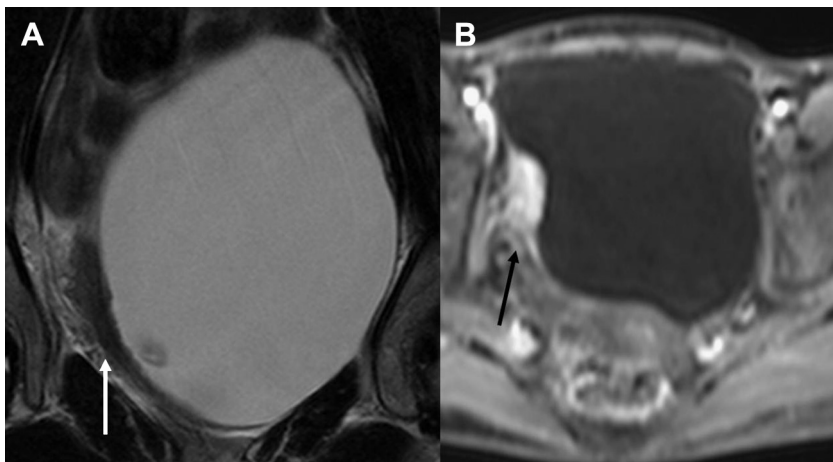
T2-weighted (A) and T1 fat saturated postcontrast (B) axial images. The *arrows* indicate bladder wall invasion and perivesicle extension in keeping with a T3b tumor.
